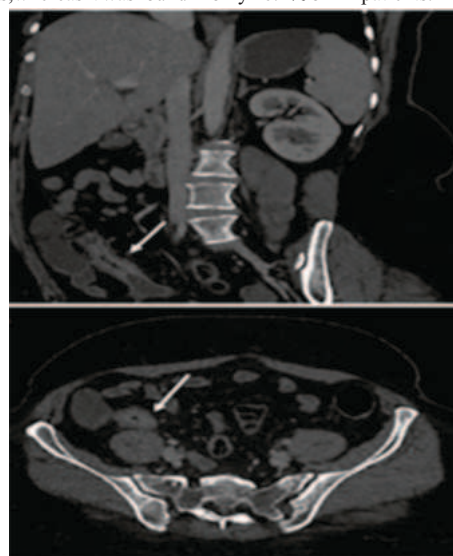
Coronal and axial contrast-enhanced CT enterography images showing small segment stricture at ileum in a patient with GITB.
